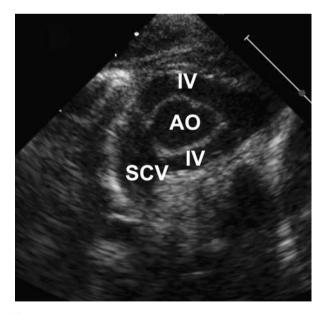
Echocardiogram. High parasternal short-axis view of the ascending aorta (Ao), innominate vein ring (IV), and superior caval vein (SCV).
